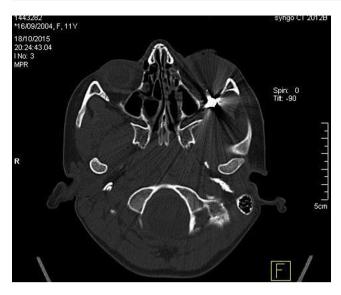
CT scan, transverse view. Intraorbital air gun pellet adjacent to the inferior orbital fissure (arrow).
